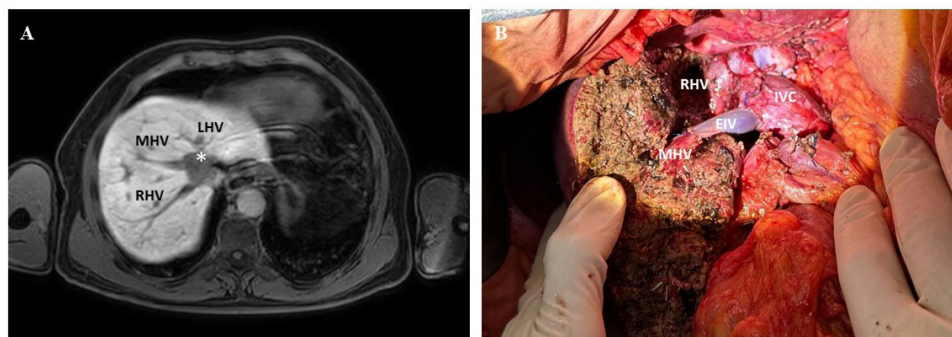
(A) The MRI scan of patient 3 shows a tumor in Sg1 (asterisk) involving LHV, MHV, RHV and IVC. (B) The operative field after left hepatectomy with caudal lobectomy and wedge Sg8 resection. MHV is resected and reconstructed with an interposed allogenic external iliac vein graft. RHV appeared not involved after intraoperative US revision (resection required inter-Laennec resection). IVC, inferior vena cava; LHV, left hepatic vein; MHV, middle hepatic vein; RHV, right hepatic vein.
